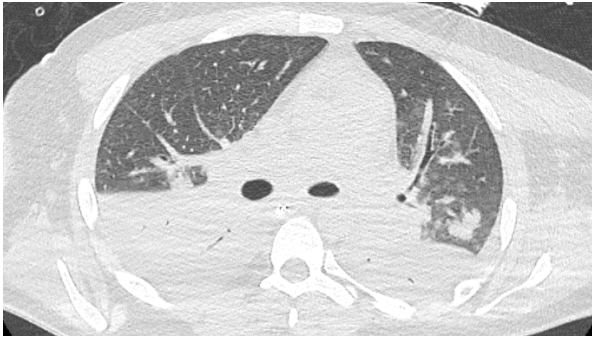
CT thoracic scanner: diffuse infectious bilateral multifocal neuropathy, predominant in the right apex as well as in the lower lobes.
